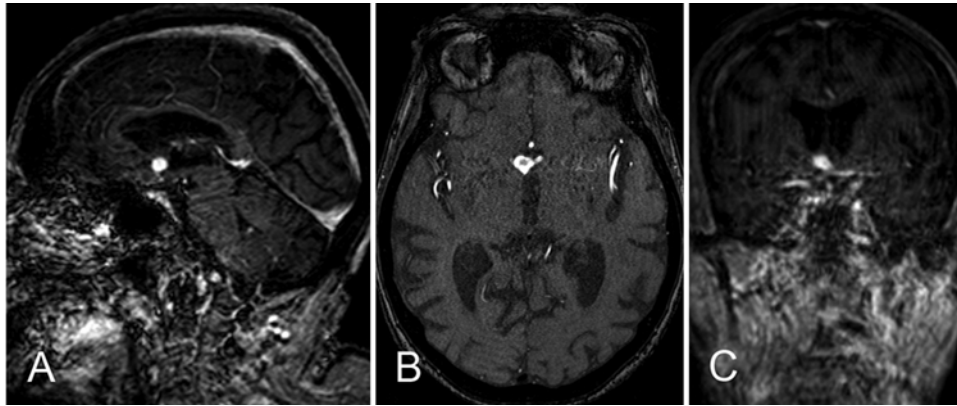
Sagittal (A), axial (B), and coronal (C) contrast-enhanced T1-weighted images obtained in a 94-year-old woman who presented with acute mental status changes following a fall. The images show an incidentally discovered anterior communicating artery aneurysm. No treatment was recommended.
